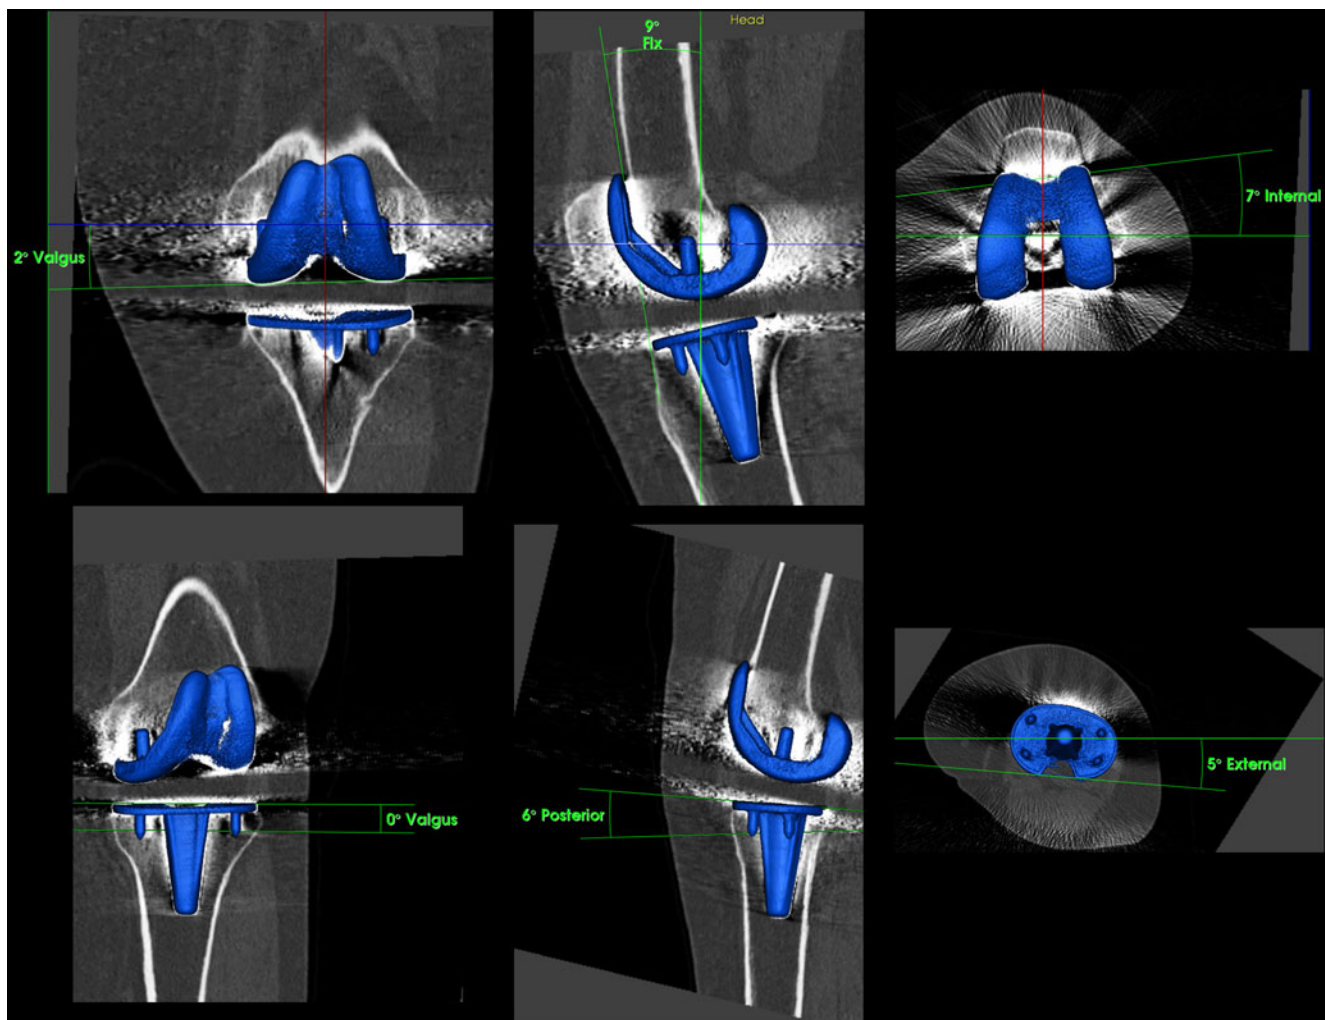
Determination of tibial and femoral total knee arthroplasty (TKA) component position (varus–valgus, flexion–extension, internal rotation–external rotation) on 3D-CT using customised software after
